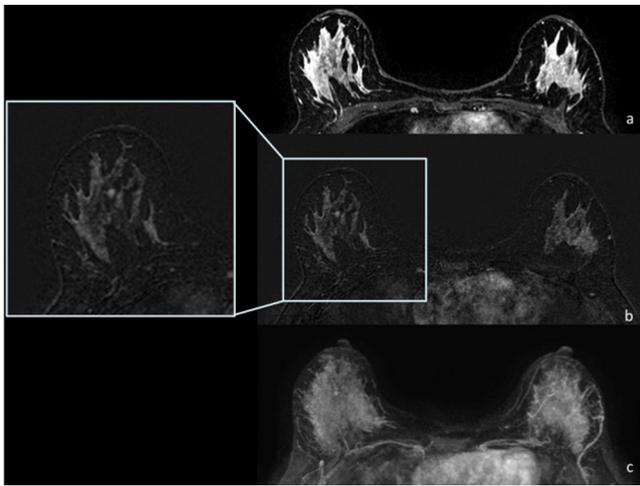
Example of BPE assessment using the four reading strategies. BPE assessment by reading: (a) the initial CE fat-suppressed T1-weighted images and (c) the MIP was marked for all the three raters, (b) the initial CE subtracted images was marked (left-sided box) for both rater 1 and rater 3, and BPE was moderate for rater 2. BPE assessment by reading the combination of all the CE sequences was marked for all the three raters. BPE assessment after consensus was marked.
